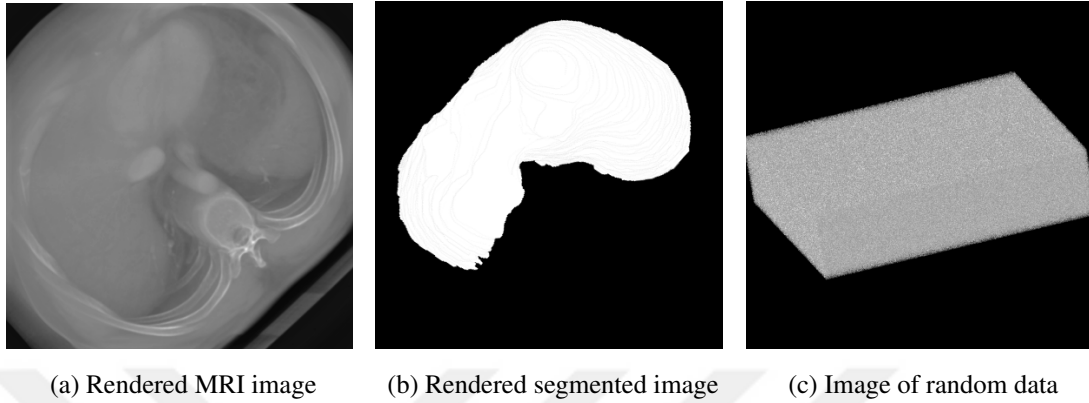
Test data: (a) Rendered MRI image (b) rendered segmented binary image and (c) uniformly distributed random data
